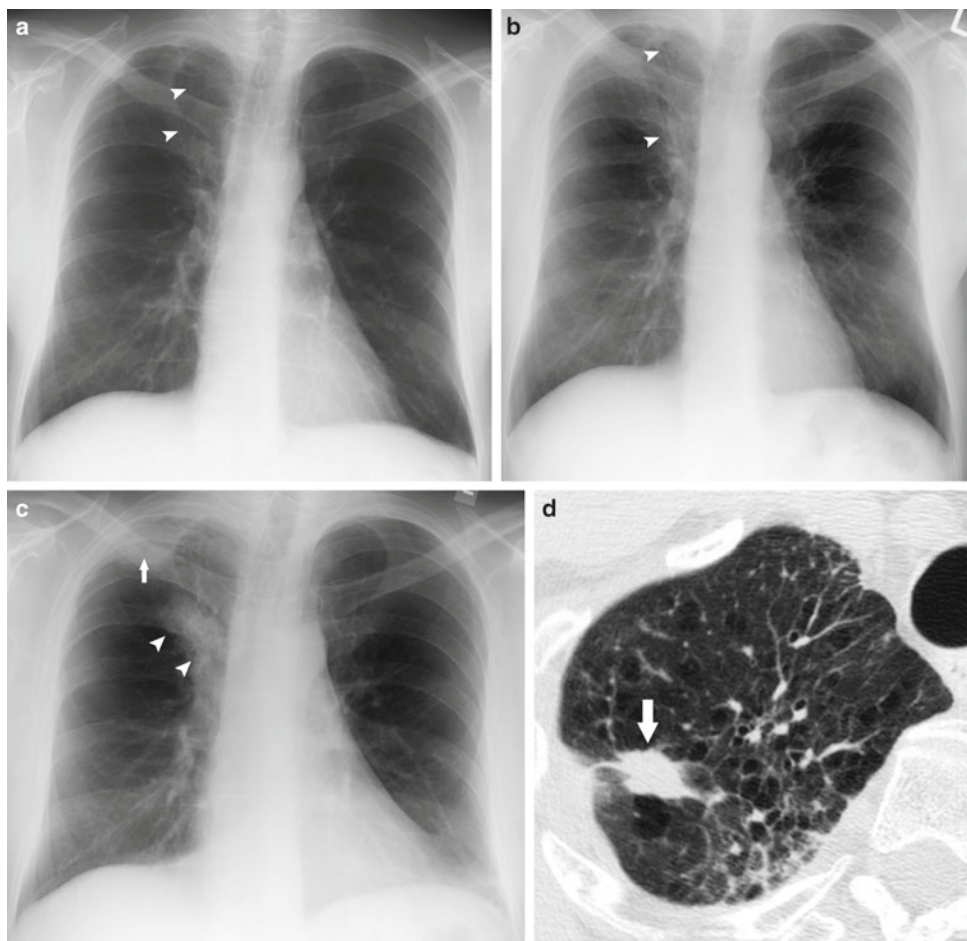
Recurrent neoplasm following radiation therapy. (a) PA chest radiograph 1 year after radiation therapy shows mild reticulation in the right upper lobe (*arrowheads*). (b) PA chest radiograph 1 year later shows increased right upper lobe consolidation and reticulation
